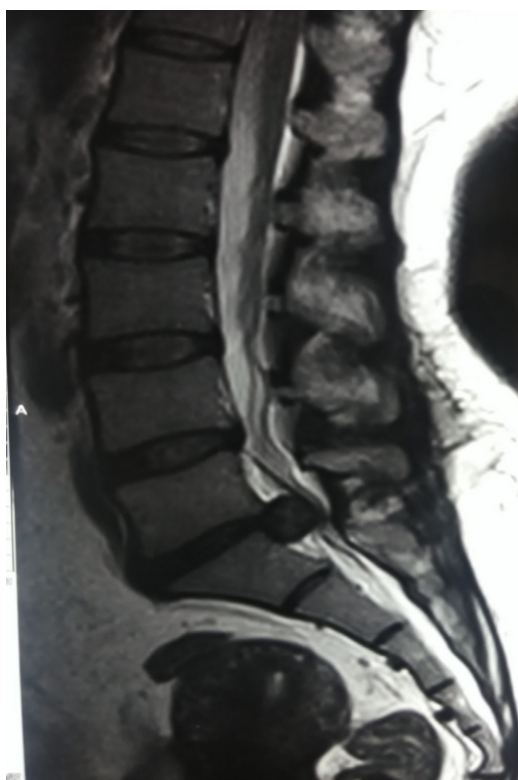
MRI lumbosacral spine sagittal section showing extruded disc at L5-S1 level
